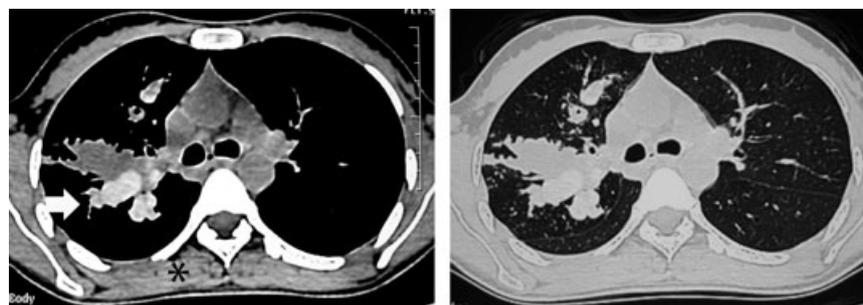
High-resolution CT (HRCT) chest showing the presence of high-attenuation mucus (bold arrow) in the mediastinal windows with corresponding lung window sections. The mucus is visually denser than the paraspinal skeletal muscle (asterisk).
